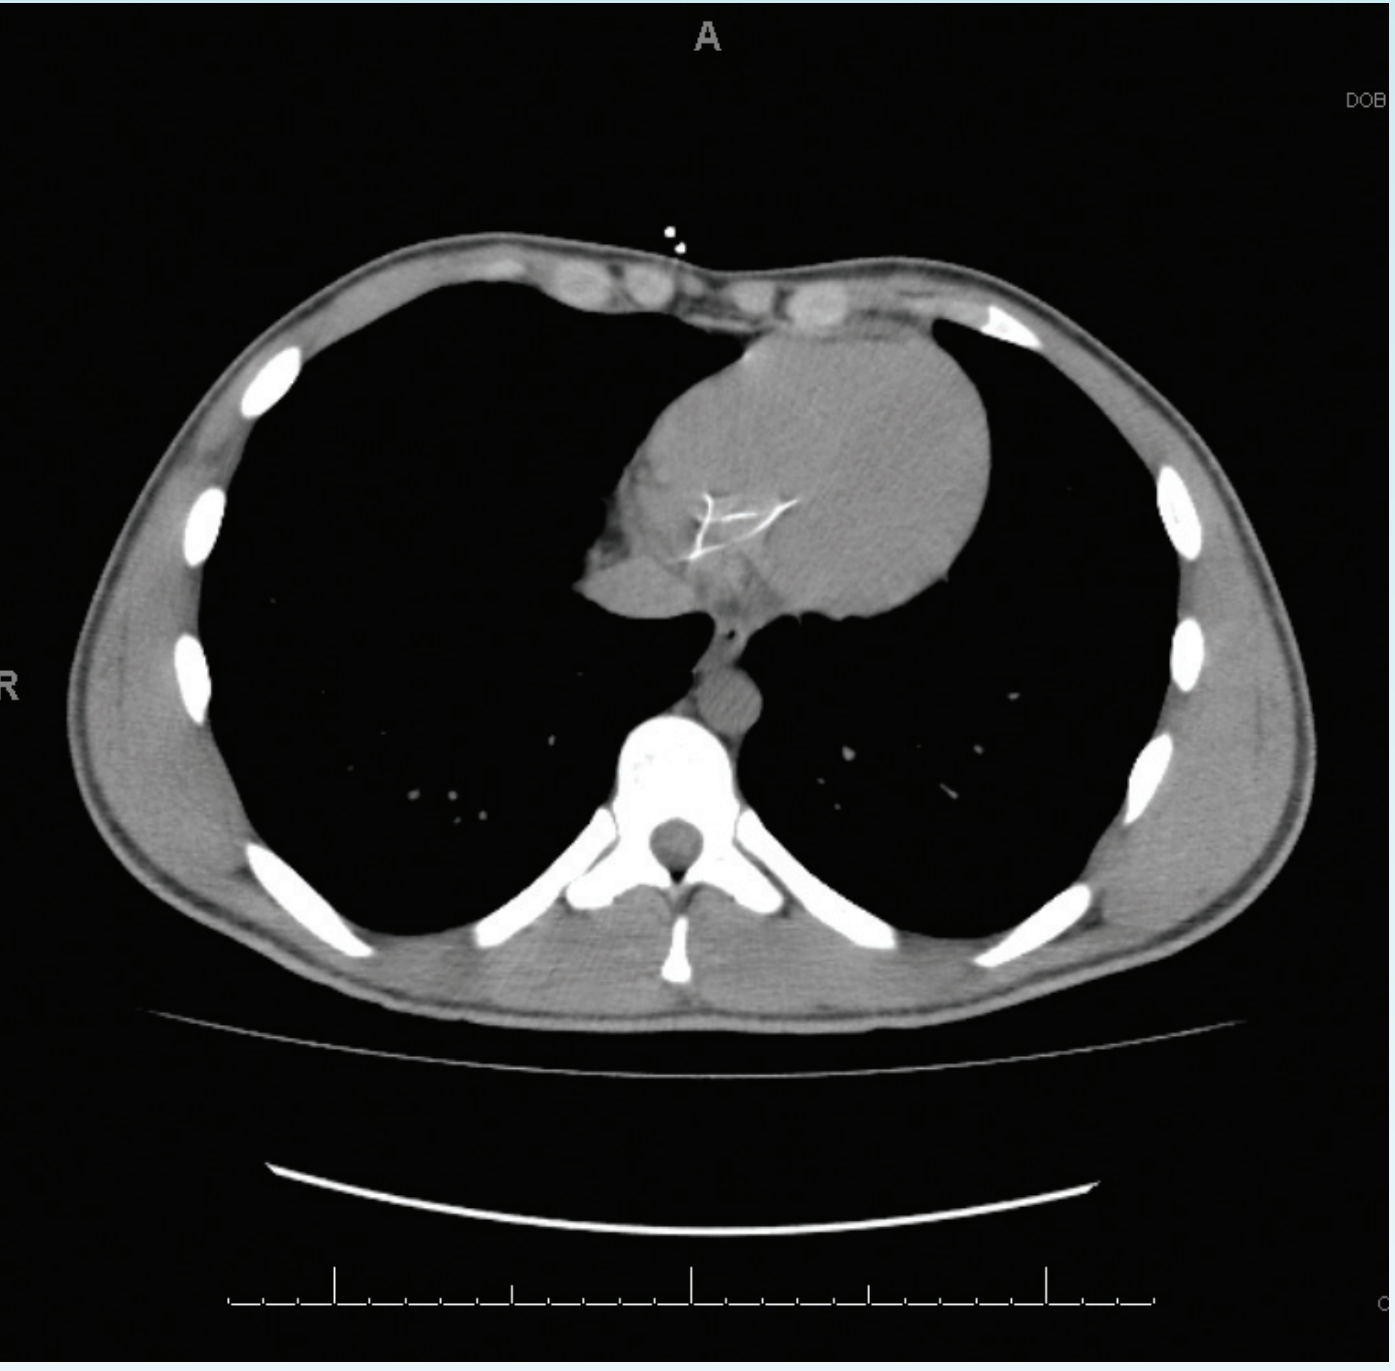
CT scan of the chest with centering strut visualized in right atria 9/17/09
